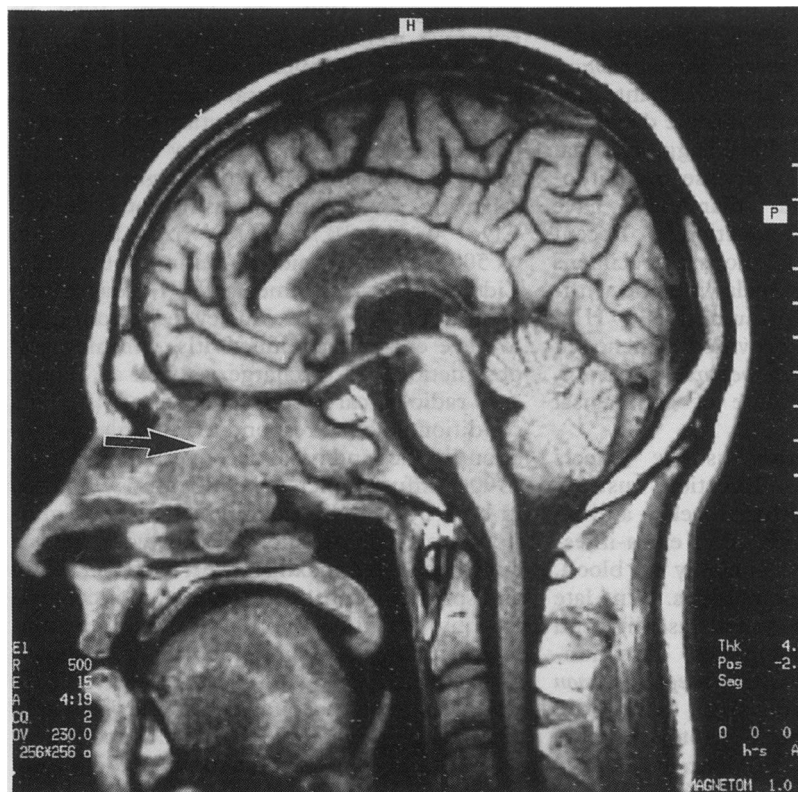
Sagittal magnetic resonance image showing inflammatory mass filling the nasal airway (arrowed) and sphenoid sinus.
